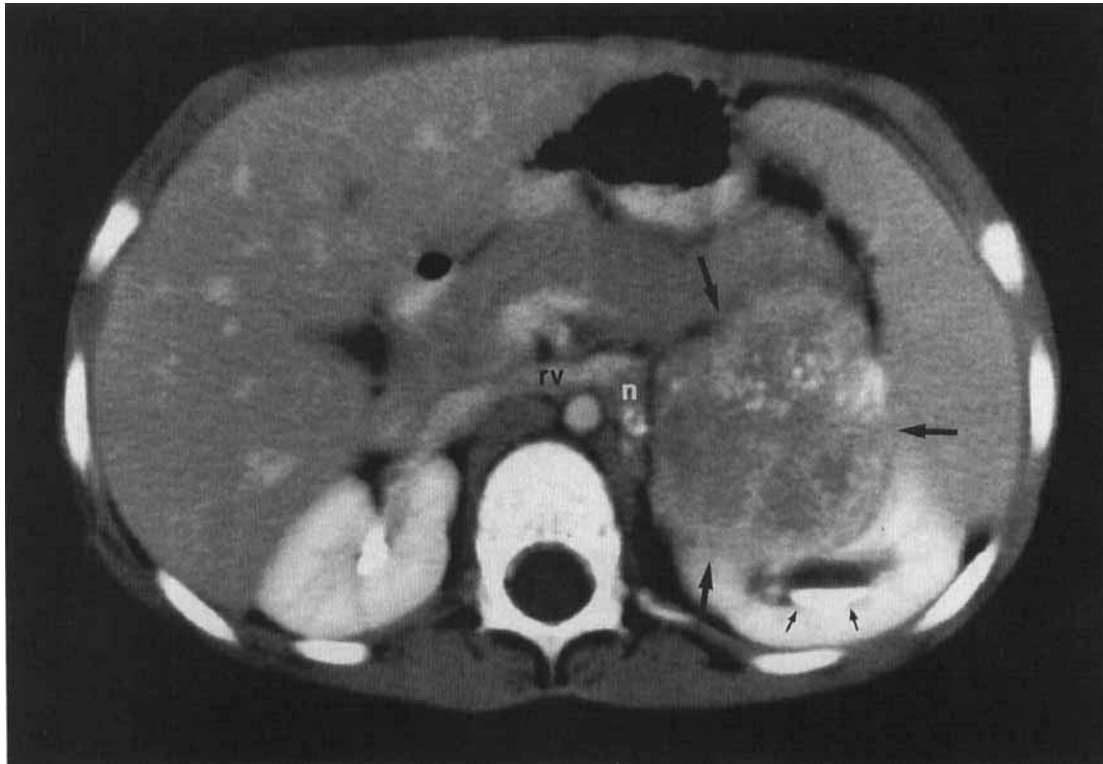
Abdominal CT. A large mass (large arrows) compresses the kidney and possibly invades that organ. Abbreviations explained in text.
